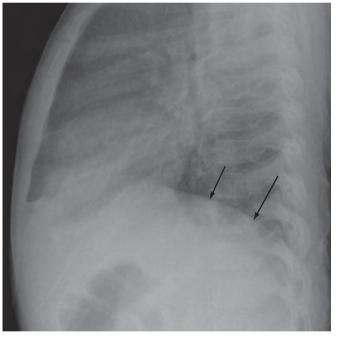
Usefulness of a lateral image: a 2-year-old boy with a cough and fever. The frontal radiograph (A) demonstrates a subtle increased density in the right lower lobe (*curved black arrows*). However, on the lateral radiograph (B), the left hemidiaphragm is easily visible (*arrows*), while the right hemidiaphragm is obscured by consolidated lung.
